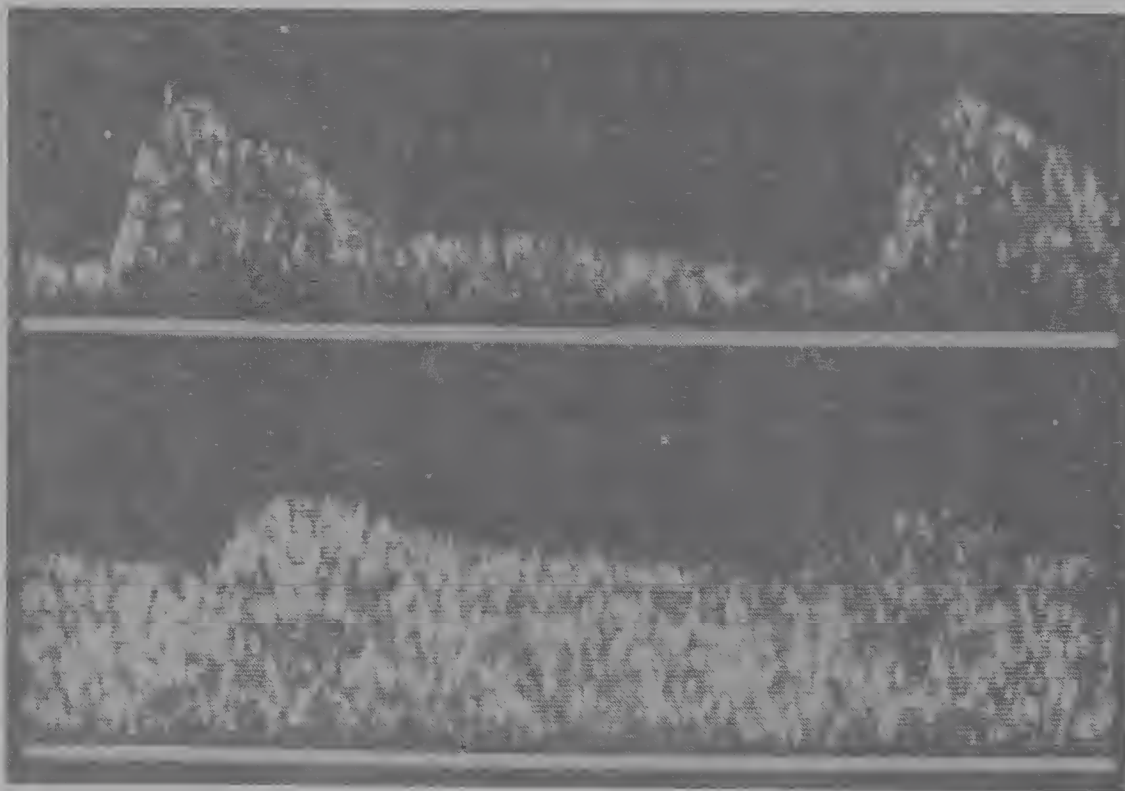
Top*, Abnormal doppler wave form from the uteroplacental circulation at first examination (16–22 weeks) with a high resistance pattern and elevated resistance index of 0.65. *Bottom*, Normal doppler wave form resistance pattern with a resistance index of 0.36. Courtesy of Dr. S.A. Steel and her colleagues at St. George's Hospital, London, U.K.
